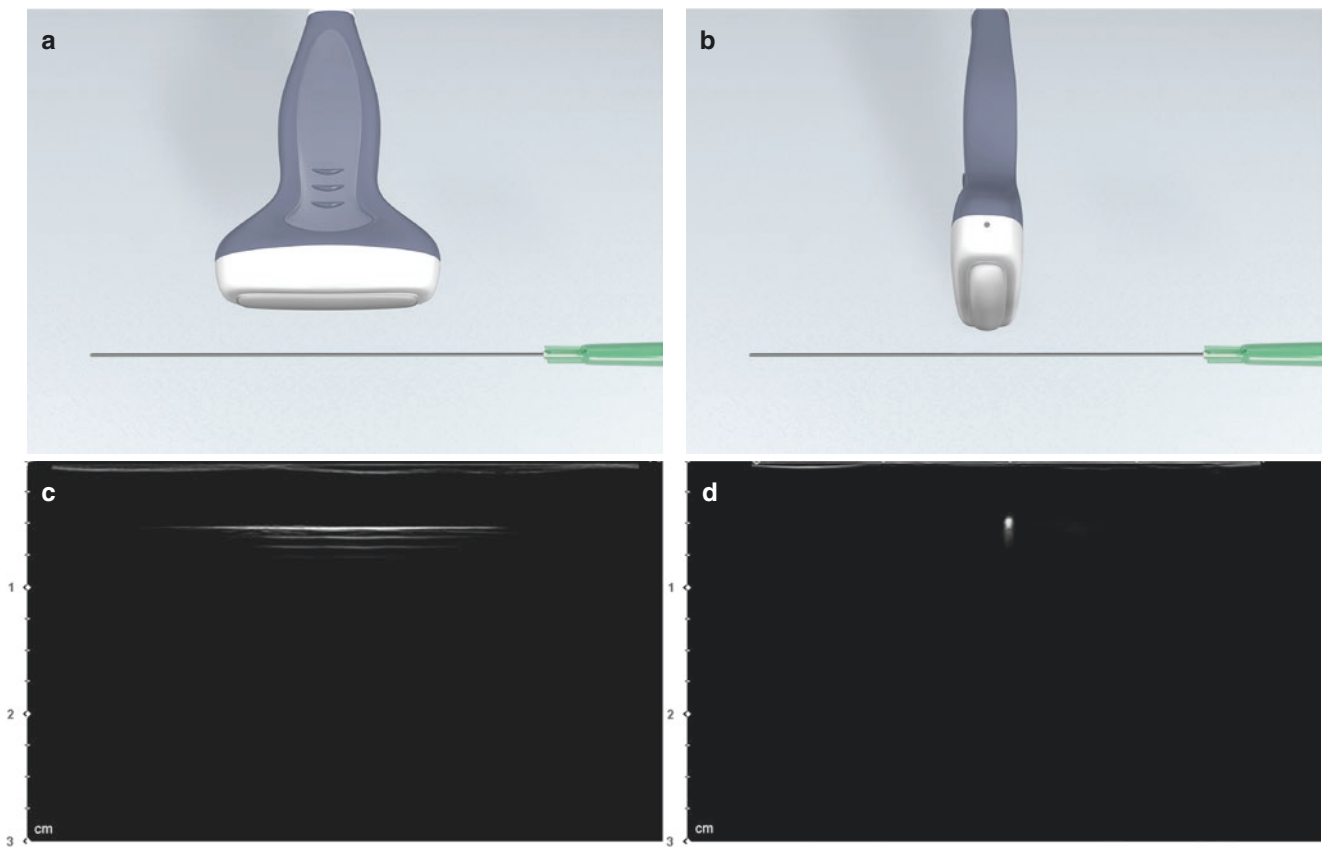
Two views of ultrasound-guided injection. (a, c) Long-axis or in-plane view and (b, d) short-axis or out-of-plane view. (Published with kind permission of © Hee-Jin Kim and Kwan-Hyun Youn 2020. All Rights Reserved)
